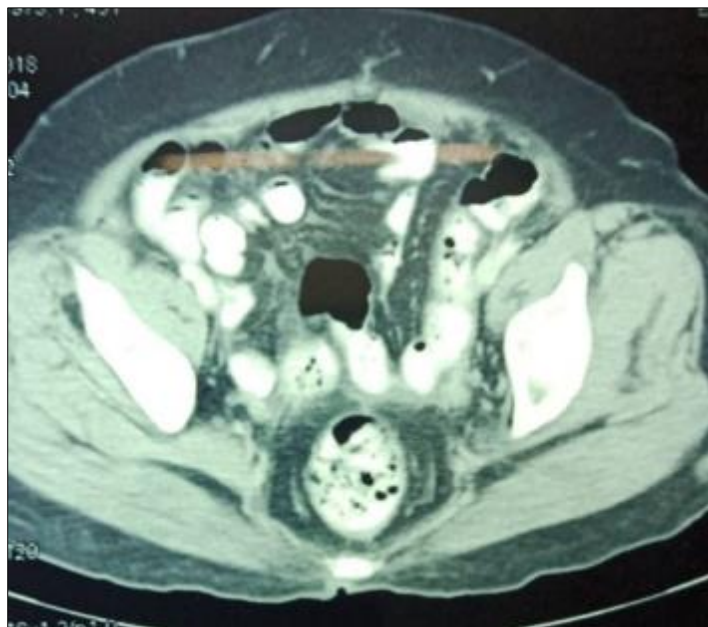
CT (Abdomen +Pelvis) - scan before bevacizumab
